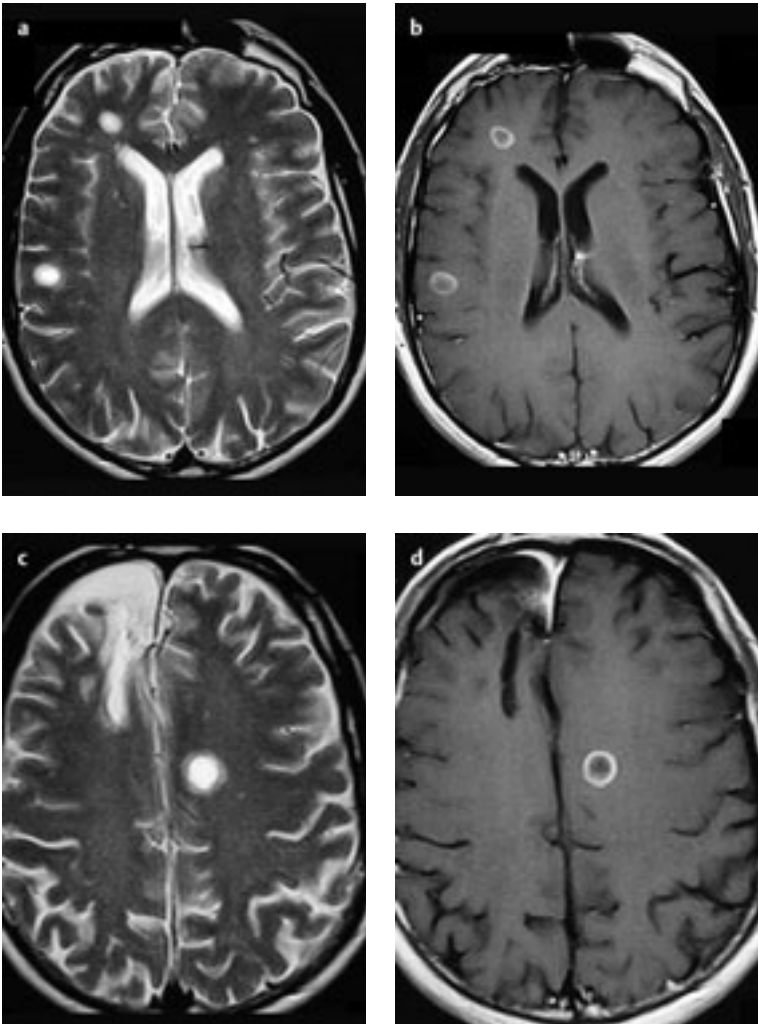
Postinfectious encephalomyelitis or acute disseminated encephalomyelitis (ADEM). Axial T2-weighted MR images (a, c) and axial T1-weighted MR images after contrast administration (b, d). Multiple subcortical hyperintensities on T2-weighted MR images that are ring-enhancing on T1-weighted MR images. Identical enhancement in all lesions (b, d). The patient had undergone surgery to remove an oligodendroglioma and received chemotherapy several weeks previously. Right frontal postoperative tissue defect.
